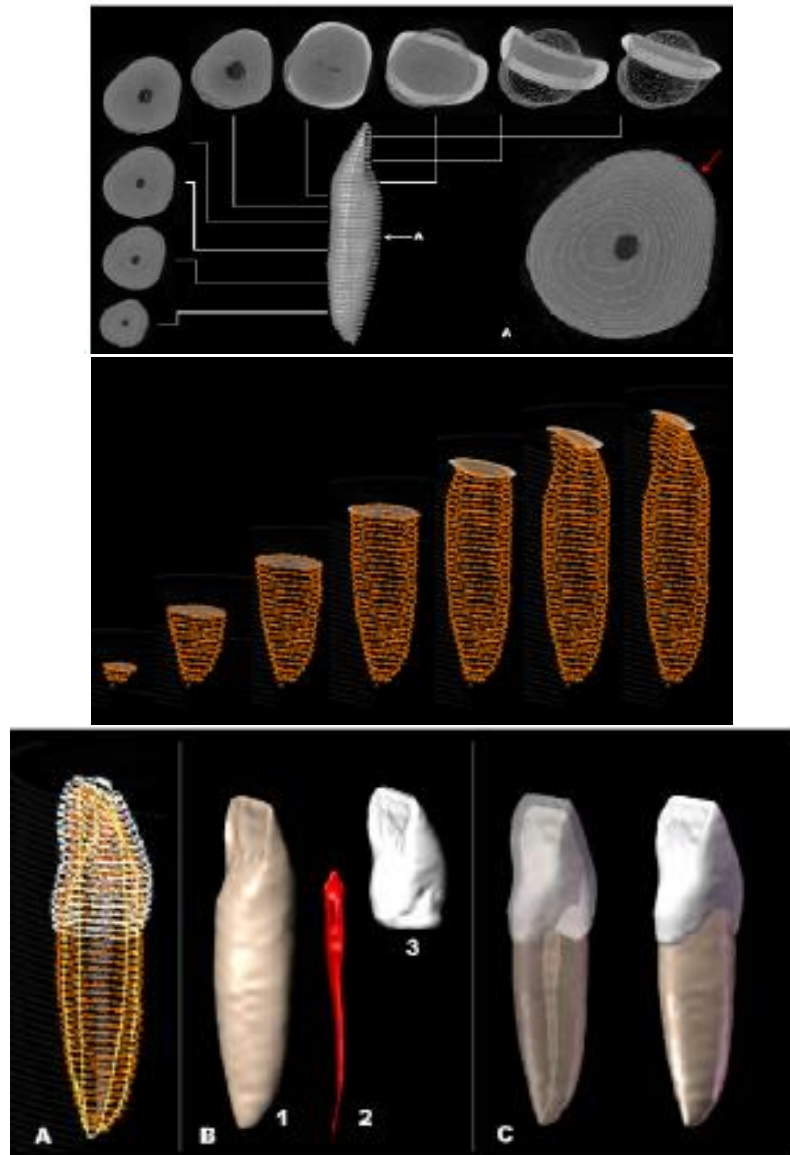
Process of developing a 3D model of a maxillary central incisor through the μ CT images [16].
